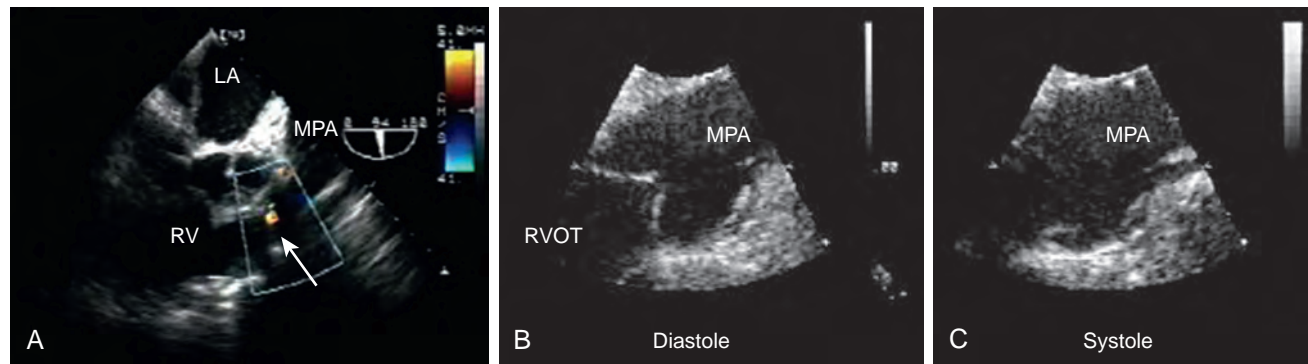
Right ventricular failure: epicardial scanning. The images shown are those obtained after homograft replacement of the pulmonary valve as part of a Ross procedure. There was significant right-sided heart failure. Transesophageal echocardiography imaging was not possible; however, epicardial imaging showed a normal functioning pulmonary valve. Further assessment showed that the pulmonary artery anastomosis created significant narrowing and obstruction to flow.
